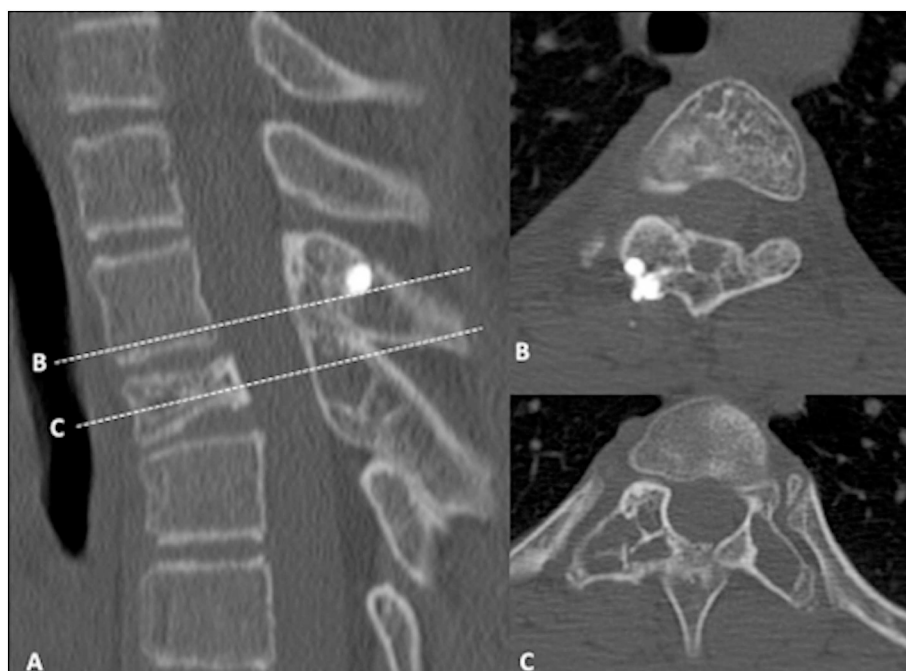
Monitoring CT-scan AT 2,5 years showing sclerosis of the lesions with reossification of the cortical BONE (A) sagittal view B) & C) axial view through T3 and T4 level) leading to stabilisation of the compression fracture of vertebra T4: reconstruction of a bone matrix within the spongy bone of the vertebral body. Reossification of the posterior vertebral wall of this vertebra is also seen.
